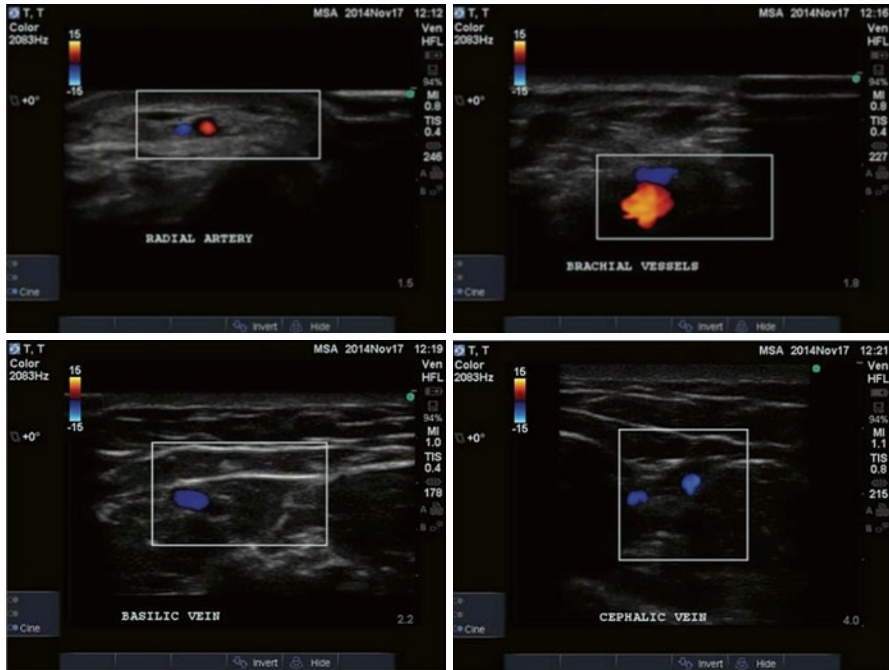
Ultrasound of vessels of the right upper limb. Veins are in *blue* and arteries are in *red*
